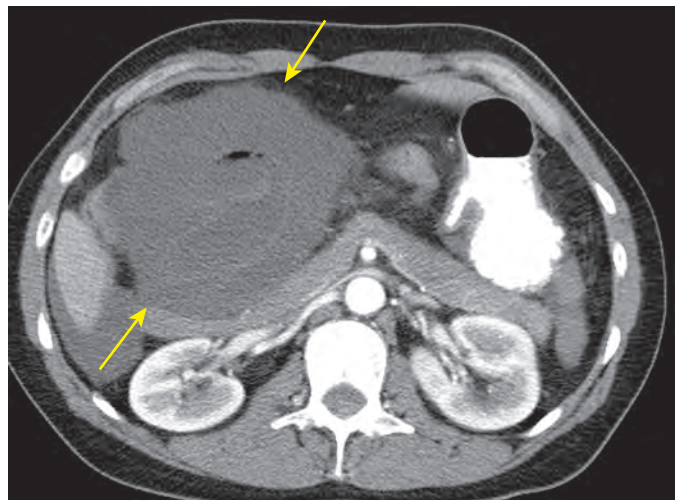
CT scan demonstrating a right paraduodenal internal hernia. There is a cluster of jejunal loops in the hernia sac (arrows) in the right upper quadrant. These loops are poorly perfused, and at surgery irreversible ischemia of the herniated intestine was found.
